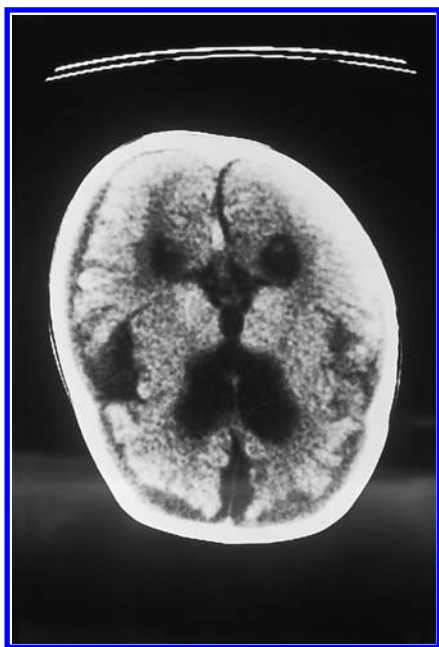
The sister of the patient in Figure 45.8. She was diagnosed late. The computed tomography (CT) scan at ten months shows considerable evidence of cerebral atrophy. She was severely impaired neurologically and died at 19 months.
